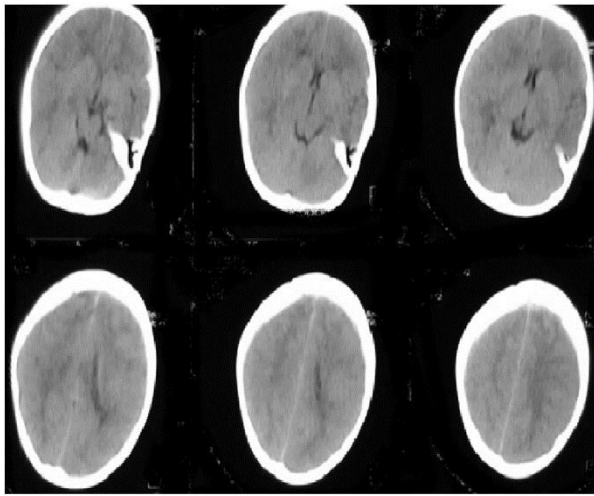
Cranial computed tomography scan following fall at previous admission showing no evidence of fracture or presence of extra-axial or intra-axial hematoma.
